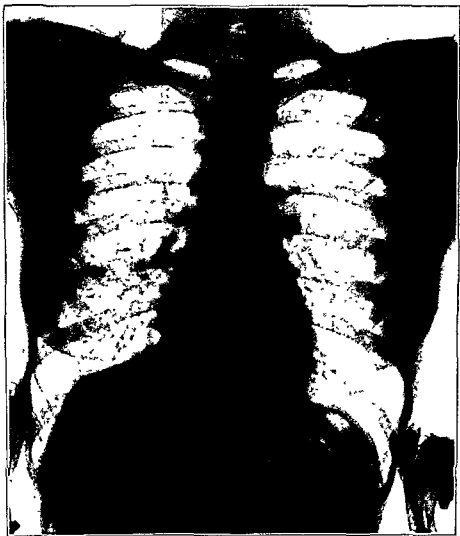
X-ray of Case No. 1 about nine months after the onset of the tuberculosis. Resolution has been almost completed
